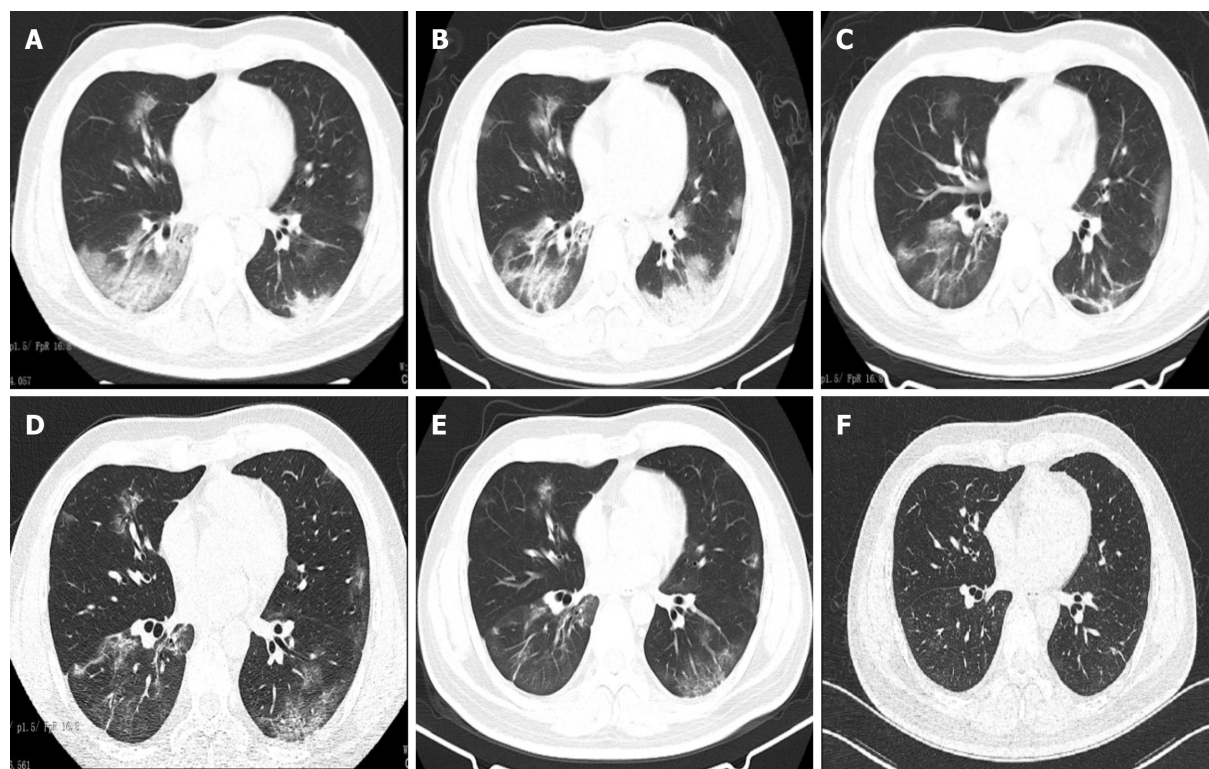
Chest computed tomographic scans in the patient with coronavirus disease 2019. A: Chest computed tomographic (CT) scan taken on hospital day (HD) 6. It revealed bilateral focal ground-glass opacity associated with consolidation in the right lower lobes; B: Chest CT scan taken on HD 9 [3 d after prone position (PP) and conventional oxygen therapy]. It revealed consolidation in the right and left lower lobes; C and D: Chest CT scans taken on HDs 12 and 15, respectively. They revealed ground-glass opacities and consolidations being dissipated during the PP and high-flow nasal oxygen therapy; E: Chest CT scan taken on HD 21. It revealed further resolution of the lesions; F: Chest CT scan taken on follow-up. It was normal.
